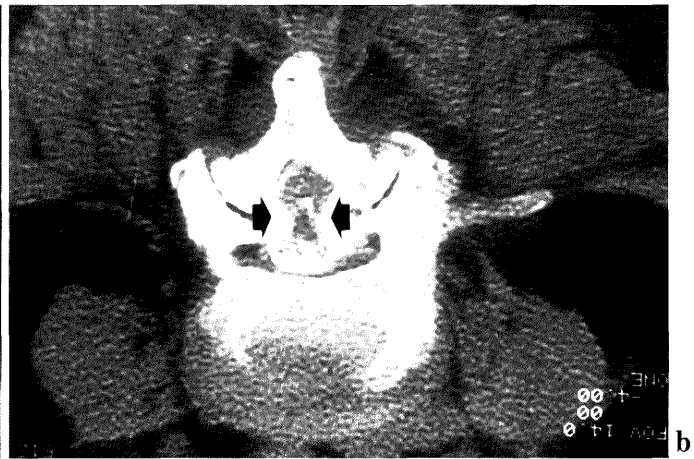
Lumbosacral myelography a with computed tomography (CT, b), revealing that the conus medullaris is compressed at the L4/5 level by bilateral bony spurs around the facet joint indicated by *arrows b*.
